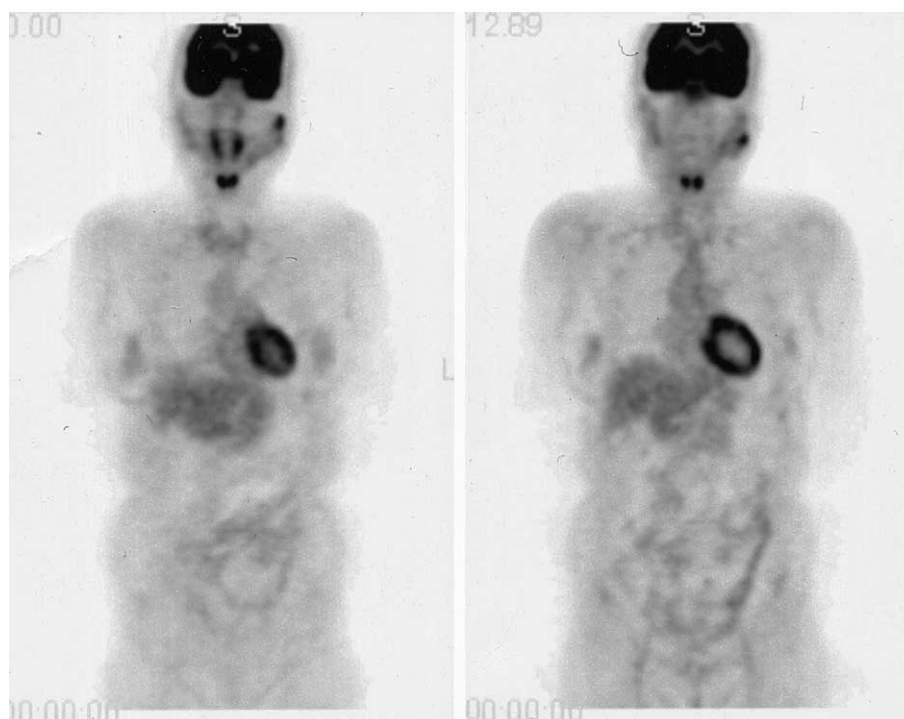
F-18-FDG whole body PET demonstrating multi-focal MALT lymphoma in the left parotid gland.
